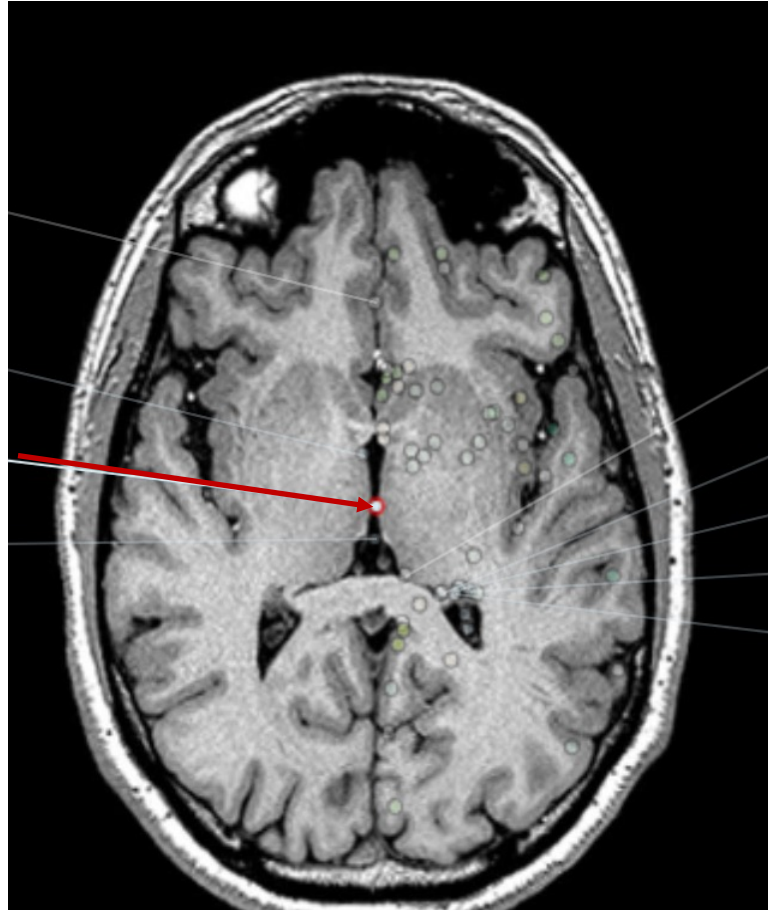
Image REF: <https://www.imaio.com/en/e-Anatomy/Head-and-Neck/Brain-MRI-3D>
